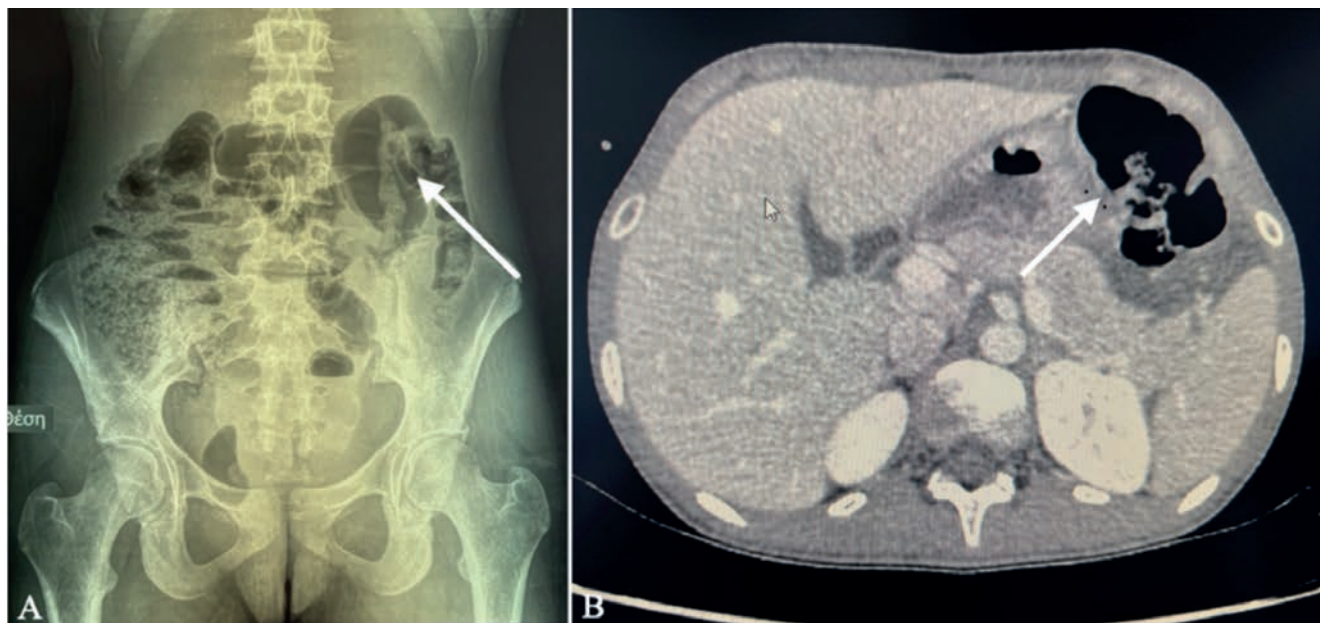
Preoperative imaging of Case 1. A) Abdominal radiograph demonstrating bowel gas distribution with a subtle soft-tissue density in the left upper quadrant (arrow), suggestive of an underlying abnormality; B) Contrast-enhanced CT scan demonstrating the small bowel intussusception (arrow).
